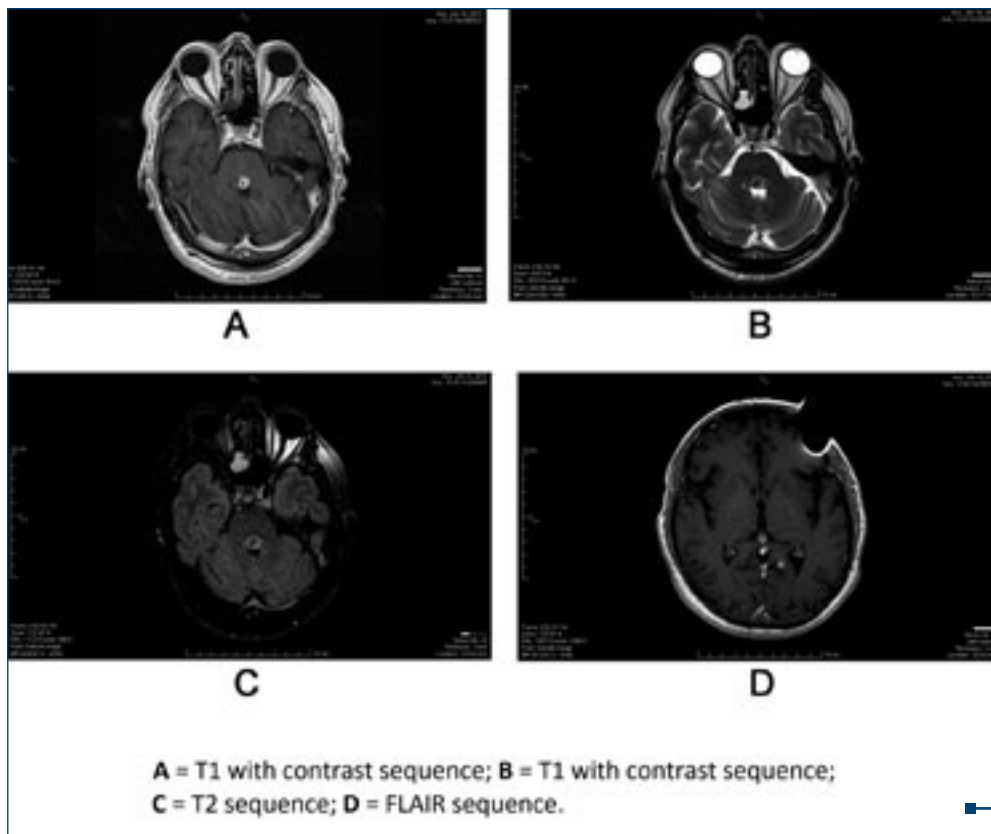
Masses identified on MRI: left paramedian medullary, medial posterior pontine, left occipital, right occipital, right parietal left parietal
